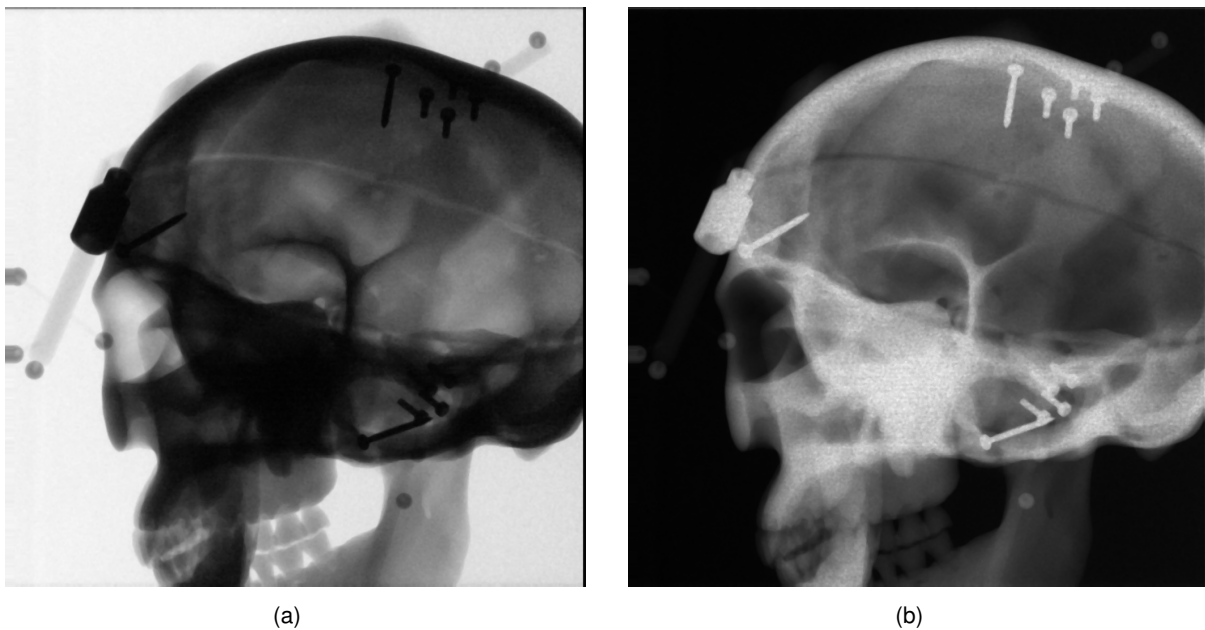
An example showing an X-ray image before (a) and after (b) applying the logarithmic scaling. The later (b) is provided as output for the CBCT reconstruction.
